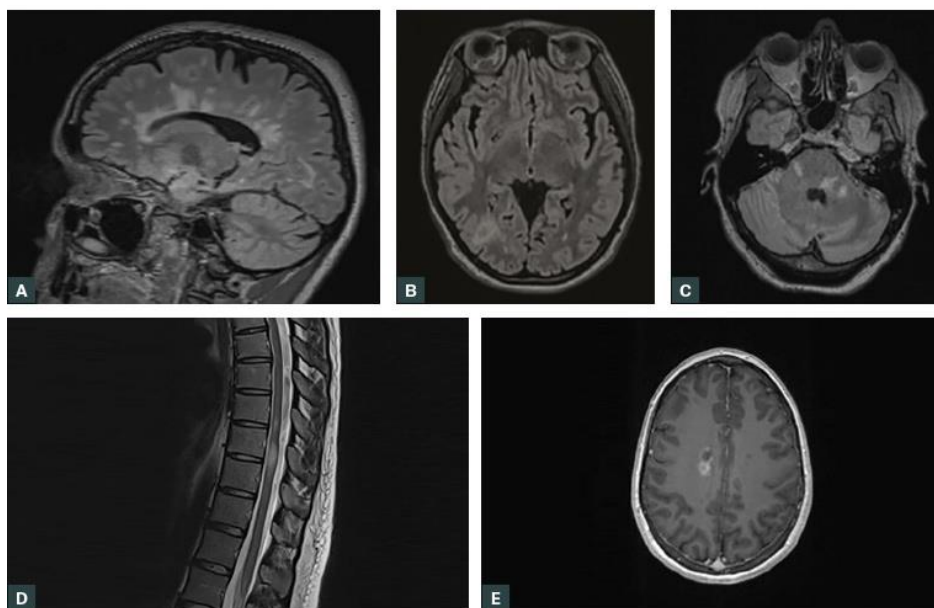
A Typical multiple sclerosis magnetic resonance imaging finding from several patients (Travers et al., 2022)
